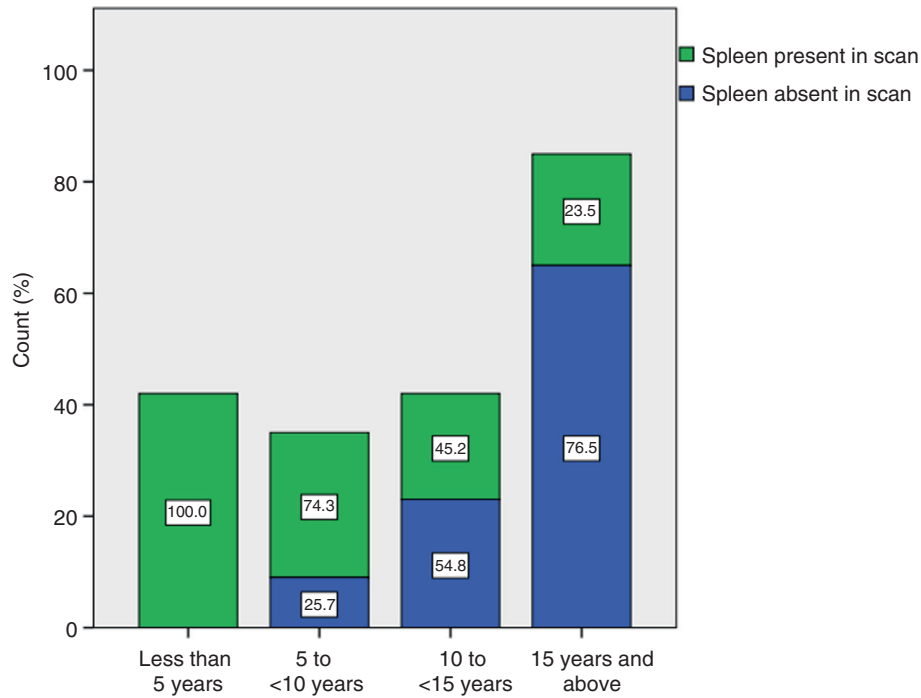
Prevalence of visualised or non-visualised spleens on ultrasonography. Stacked chart showing frequency of visualised or non-visualised spleens across age groups among patients with SCD ($n = 204$). The frequency of non-visualised spleen increased with increasing age. SCD, sickle cell disease.
